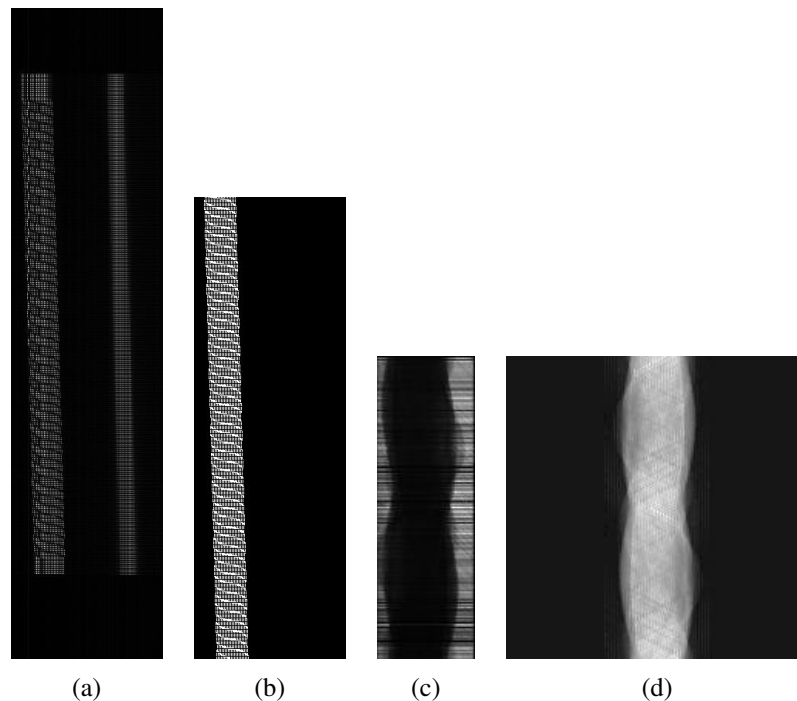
Comparison of the images of the C-arm device reconstructed with the old software (a), the new software for the C-arm device (b) and the further improved software for the CT scanner (c).
